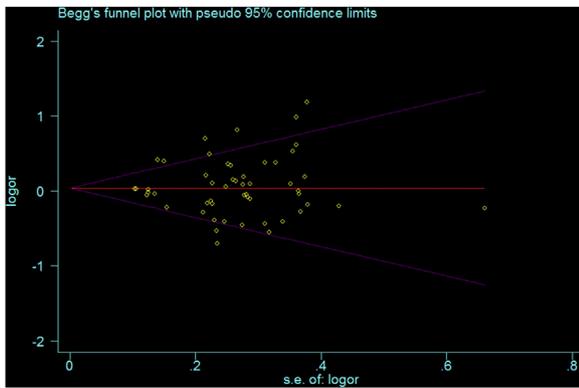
Funnel plots showing the meta-analysis of the association between the MTHFR c.677C>T polymorphism and risk of cleft lip with or without cleft palate in the dominant model (CT + TT/CC). MTHFR: methylenetetrahydrofolate reductase; C = cytosine; T = thymine.
